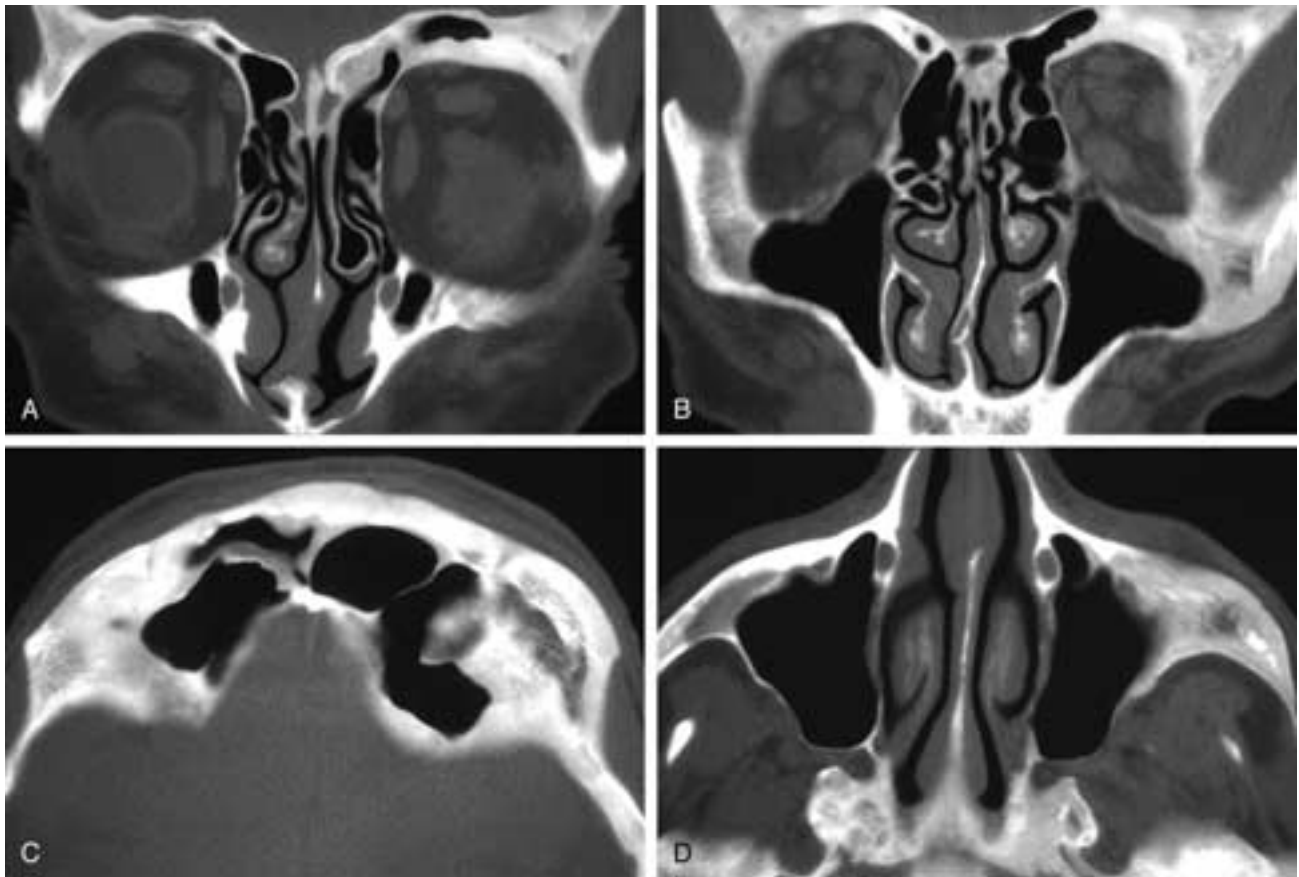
Coronal (A and B) and axial (C and D) CT scans show the facial bones to be thickened, denser than normal, and with poorly defined trabeculae. Similar changes were present in the calvarium. This patient had Paget's disease.
